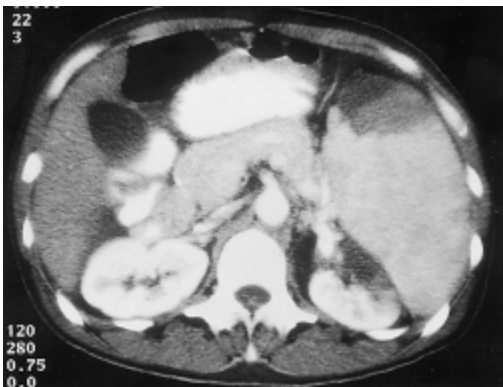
Computed tomography of the abdomen showing large embolic infarcts in the spleen and left kidney of a patient with *Bartonella* endocarditis.
